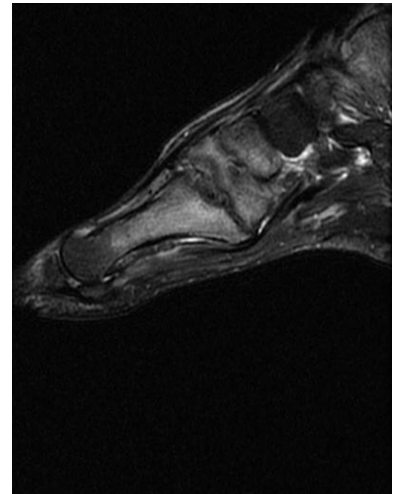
Magnetic resonance imaging of the right foot showing erosion of the articular surfaces of the right first tarsometatarsal joint with joint effusion and prominent periarticular bone marrow edema.
